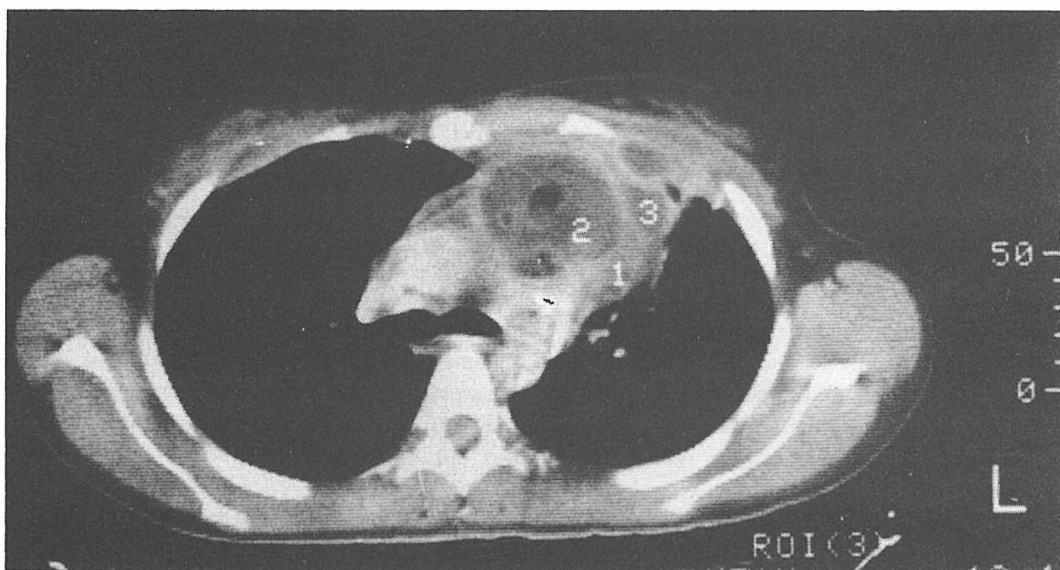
Transversal CT slice at the level of tracheal bifurcation: clear presentation of the relation between the voluminous cystic tumorous mass of the front mediastinum and thoracic wall and vascular structures (Op. P. H. D.: teratoma cysticum).
